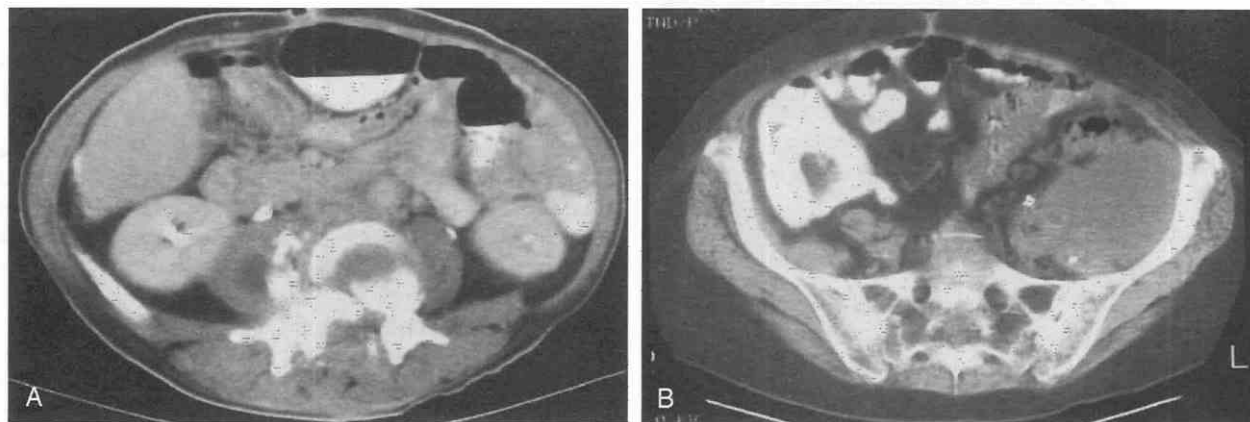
Iliopsoas abscesses. *A*, A nondynamically enhanced CT scan shows a low-attenuation mass within the right psoas muscle. At surgery, the mass contained purulent material. *B*, An unenhanced CT scan from another patient shows a large iliopsoas abscess on the left that was successfully managed by percutaneous drainage.
